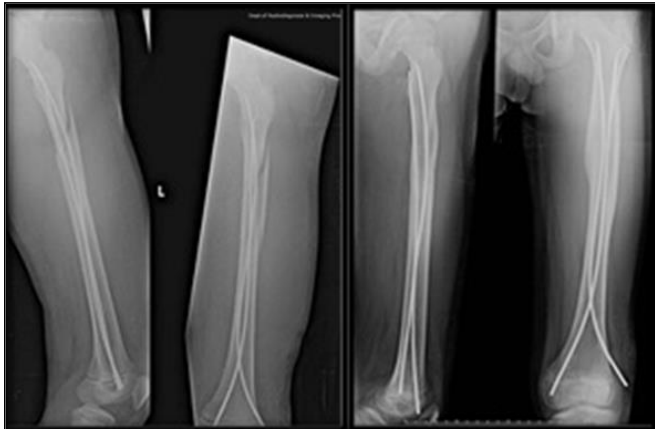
Shaft of femur fracture with immediate post operative and 1 year follow up radiograph
